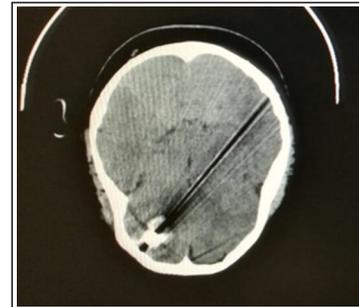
Axial non-contrast CT scan showing the metallic foreign body traversing the right frontal bone with associated intraparenchymal hematoma.
